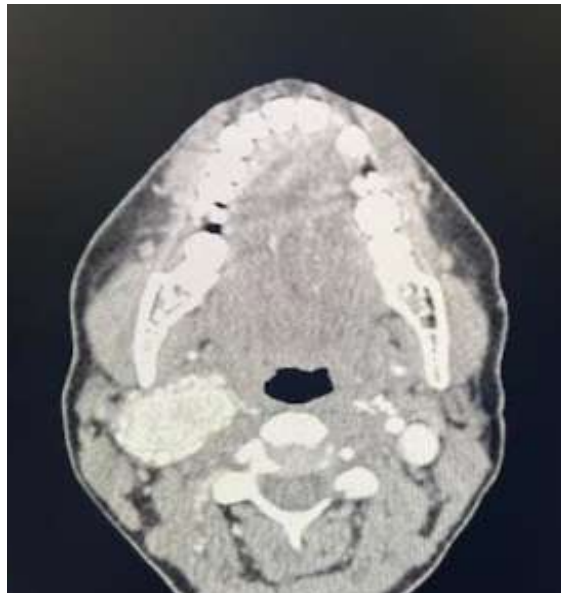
Axial cross-section of a contrast enhanced CT angiography showing a right carotid paraganglioma measuring 44x37x60 mm in diameter prior to radiotherapy
